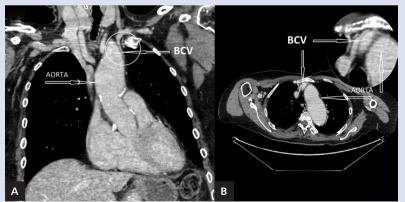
Computed tomography; A. Coronal plane: flattened left brachiocephalic veins (BCV), moulded by the enlarged aortic arch; B. Transverse plane: slit-like lumen of the left BCV due to the enlarged stent-fortified aorta
